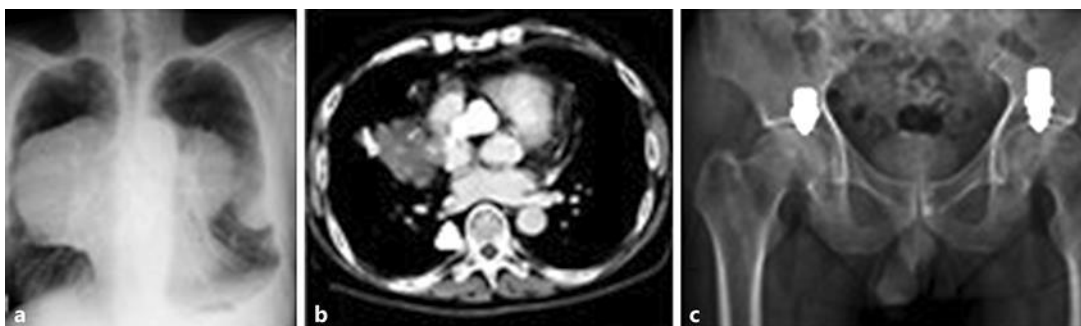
Case 2 was a 53-year-old male with malignant thymoma who was receiving chemotherapy. a The initial chest X-ray showed a large mediastinal mass. b The chest CT scan (axial view) revealed a tumor or thrombus over the right posterior proximal pulmonary vein and left atrium (arrowhead). c The pelvis X-ray showed bilateral osteonecrosis of the femoral heads (arrows).
